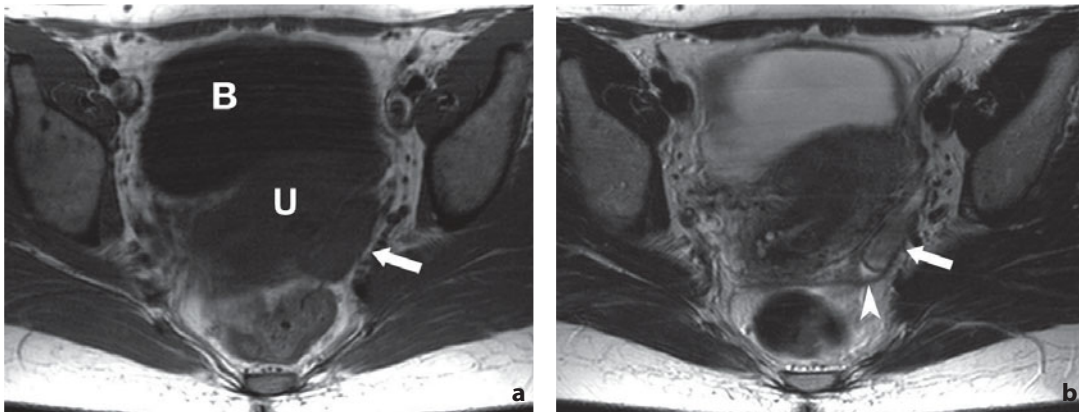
Magnetic resonance. Pyosalpinx. Axial T1- (a) and T2-weighted (b) images show mild swelling of the left uterine tube (arrow), adjacent to which is a small amount of inflammatory liquid (arrowhead). U, uterus; B, urinary bladder
